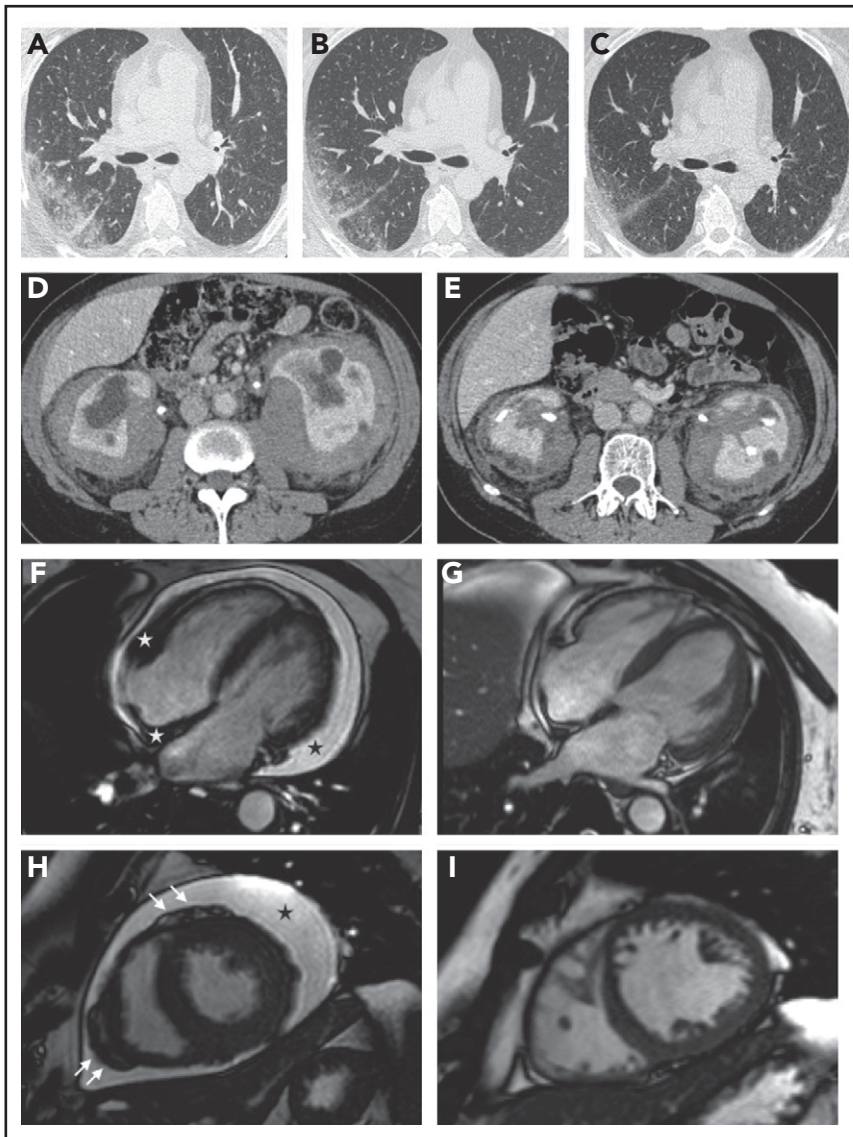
Organ responses. (A-C) Chest high-resolution CT scans in patient 12 show progressive regression of ECD-related lung disease (the scans were taken respectively before treatment and at months 6 and 12 after the beginning of therapy with everolimus) (axial view). (D-E) Contrast-enhanced abdominal CT scans in patient 8 show marked regression of perirenal infiltration with consequent improvement of hydronephrosis and calycectasia (axial view). (F-I) Cardiac magnetic resonance (cine frame from steady-state free precession sequence) in a patient (#19) with cardiac involvement; the scans were taken at baseline (F,H) and after 1 year of treatment (G,I). (F) Circumferential pericardial effusion (black star) and pathologic soft tissue in the right atrioventricular groove and the right side of the interatrial septum (white stars). Arrows (H) indicate nodular thickening of the visceral pericardium. Pericardial effusion and infiltrative lesions almost completely disappeared (G,I; scans after treatment).
